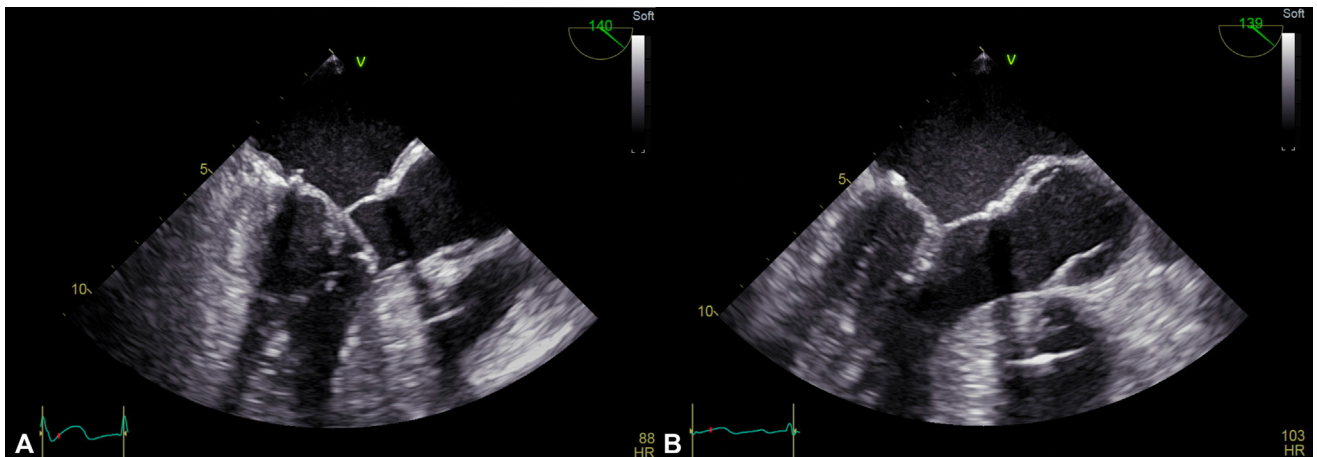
Intraoperative transesophageal echocardiogram post repair (midesophageal long-axis views). This is a case of Barlow’s disease with bileaflet (predominantly posterior leaflet) prolapse, initially repaired with P2 quadrangular resection, chordal transfer from P2 to P3, placement of artificial chordae on A2 and ring annuloplasty. A, Demonstrates significant systolic anterior leaflet motion (SAM) after separating from cardiopulmonary bypass. B, The valve repair was simply revised by transferring the island of P2 chordae, previously transferred to P3, to A2 and placing artificial chordae on the redundant P3. Demonstrates resolution of SAM after separating from cardiopulmonary bypass the second time.
